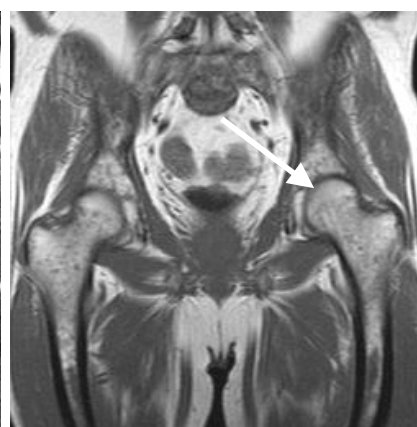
Magnetic resonance imaging of myelofibrosis. Coronal T1 spin echo picture of the pelvis showing remodeling of bone, particularly prominent in the femur heads, from before HCT to one year after HCT.
